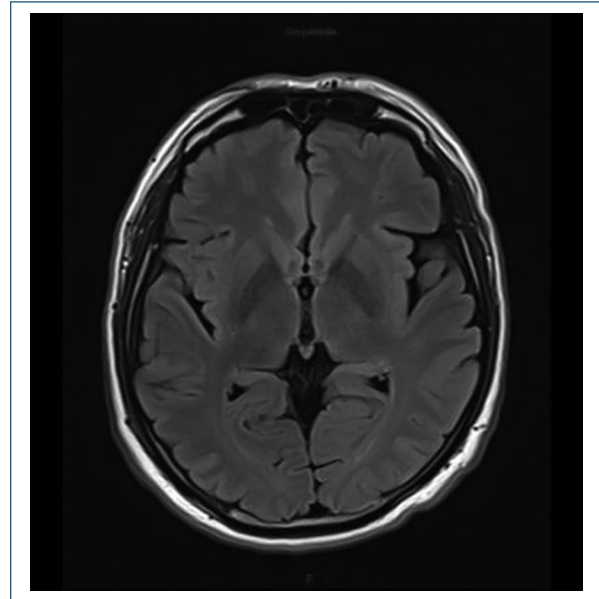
Simple MRI performed on September 5th, 2021. In the T1 phase, no evident structural disorders are seen.
